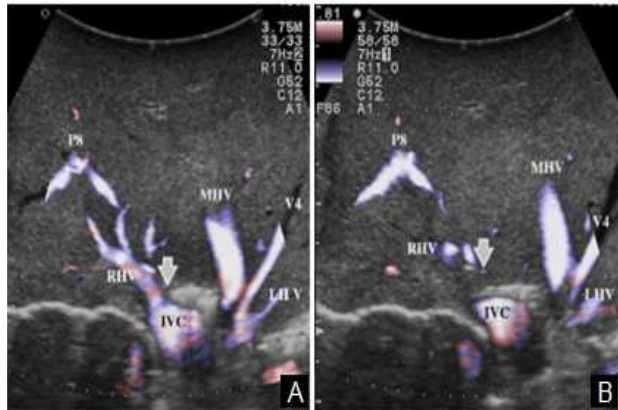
eFlow before (A) and during the ultrasound guided digital compression of right hepatic vein (RHV) (B) (săgeți). The inversion of the flow in RHV with preservation of hepatopetal flow in P8 ventral and dorsal (P8v și P8d) can be observed. MHV – medial hepatic vein; LHV – left hepatic vein; IVC – inferior vena cava.
